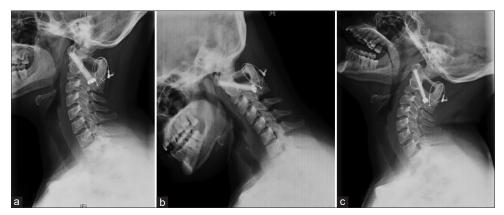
Follow-up cervical spine radiographs of the case shown earlier [Figure 3]. There is good trabecular bone formation at C1-2 (a) with reduction in atlantodental interval, and no instability in the flexion (b) and extension (c) images
